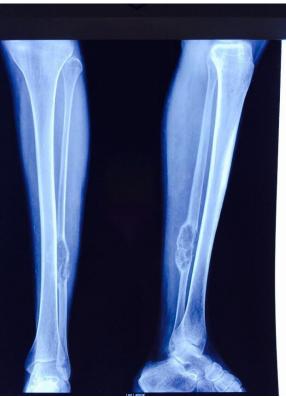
Radiograph left leg AP/lateral view
